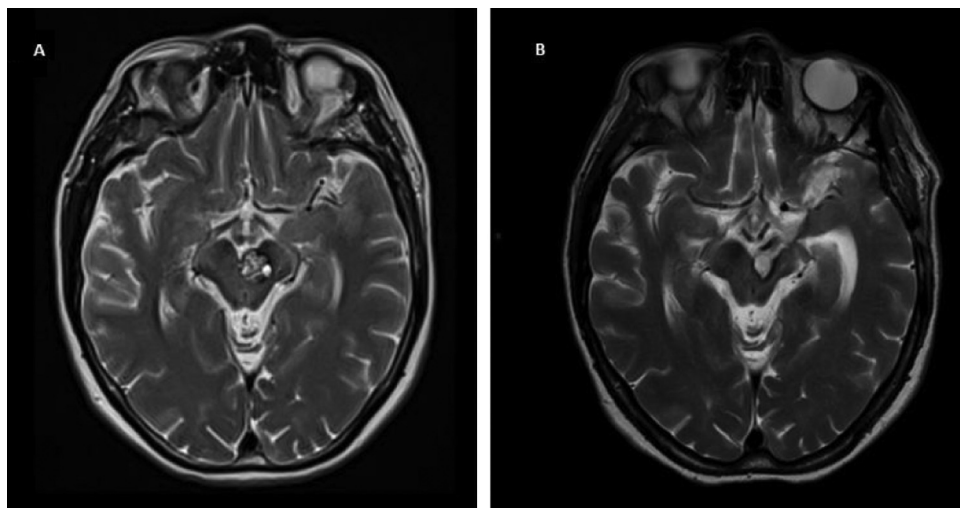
Patient 17: A. preoperative axial T2-weighted MR image showing a cavernoma in the left antéro-médian midbrain. B. Postoperative lastFUp T2-weighted brain MRI showing GTR by transsural approach
